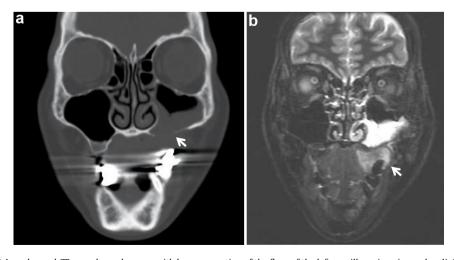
CT and MRI images (a) An enhanced CT scan showed a mass with bone resorption of the floor of the left maxillary sinus (arrowhead). (b) MRI showed hypervascular mass in gingiva (arrowhead) and an accumulation of liquid in maxillary sinus.
